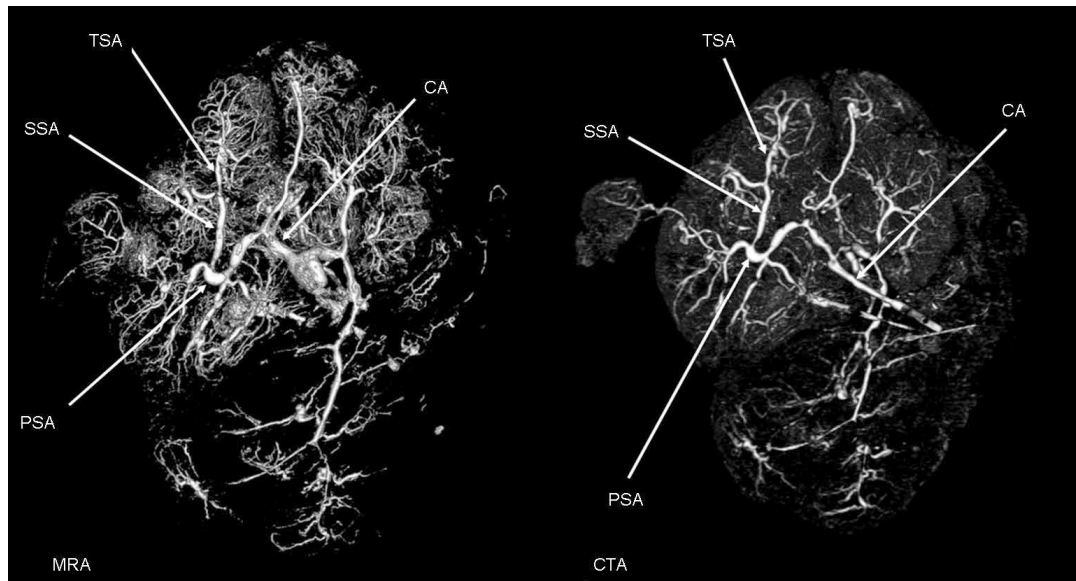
Comparison of reconstructions of the fetal placental vascular system based on magnetic resonance angiography (MRA) and computed tomography angiography (CTA) of the same human placenta. As can be seen, MRA is capable to distinguish much more small vessels than CTA. Key: CA, chorionic artery; PSA, primary stem artery; SSA, secondary stem artery; TSA, tertiary stem artery. Reproduced from Rasmussen et al. (2010)
